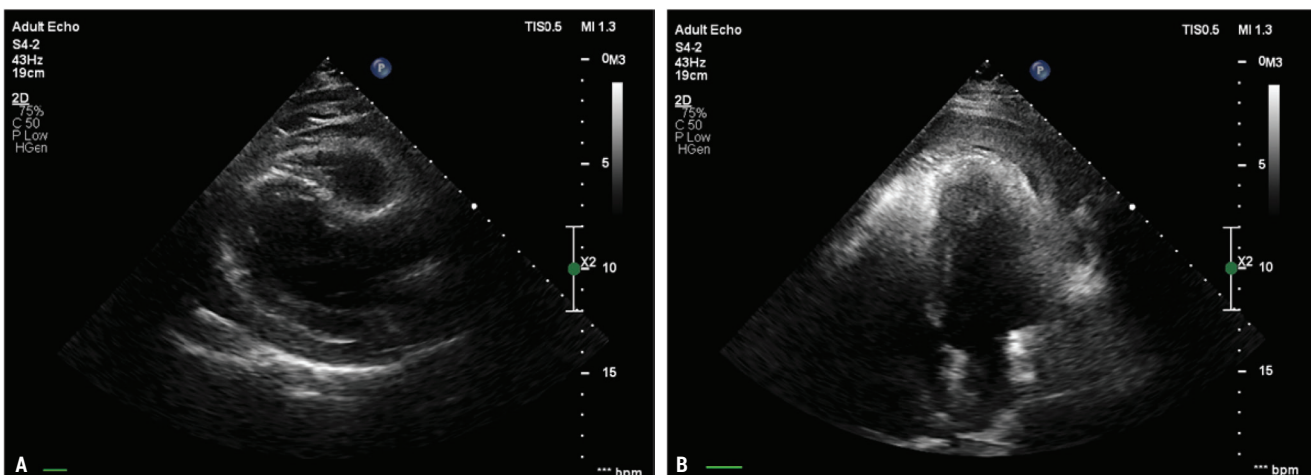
Echocardiography – large circumferential hemorrhagic pericardial effusion. A) Parasternal long axis view. B) Apical four chamber view.
